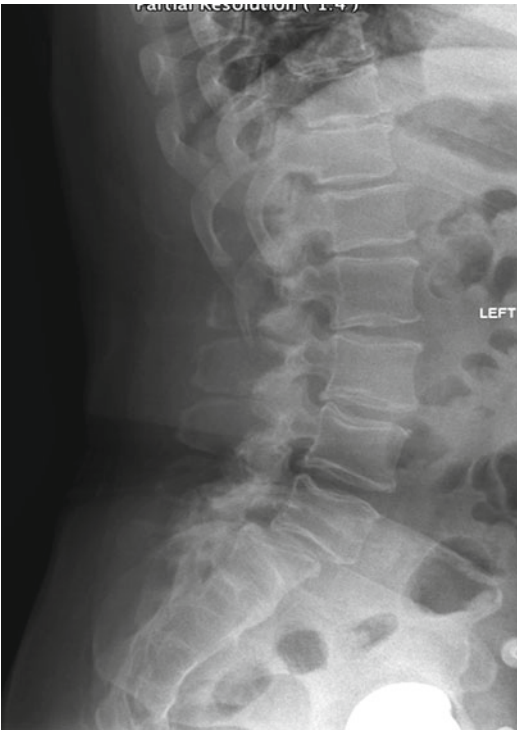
Lateral radiograph demonstrating spondylolisthesis at L5–S1
